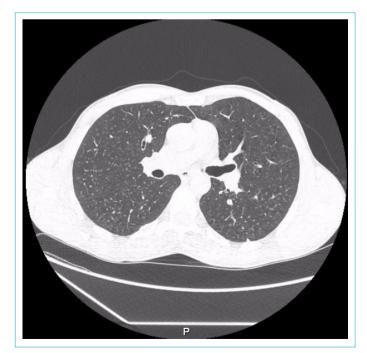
Bilateral multiple nodules on the High-resolved computed tomography (HRCT).
